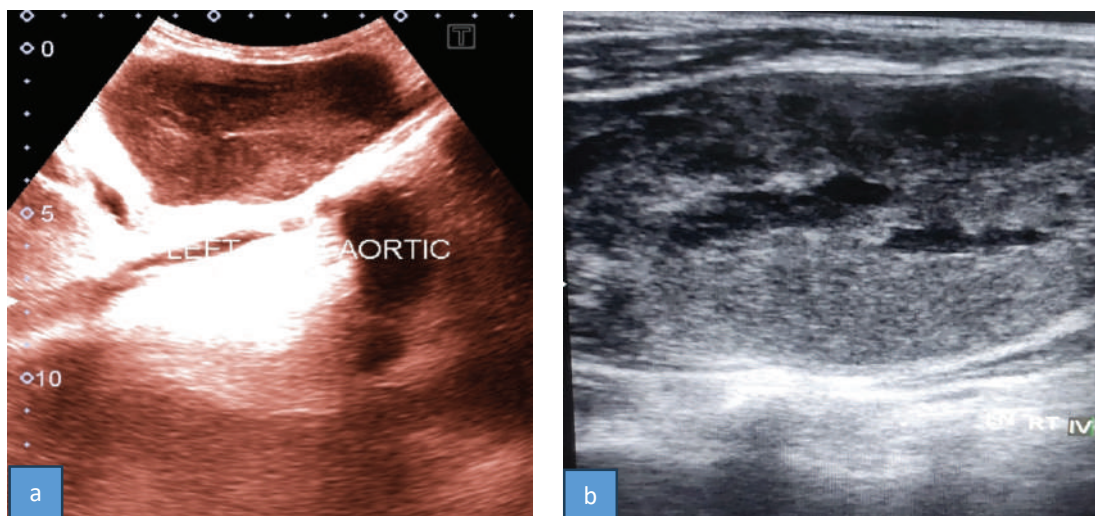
Ultrasound examination of a patient of PTC with persistently low Tg level showing multiple enlarged abdominal lymph nodes at left paraaortic (a) and right sided cervical (b) regions with loss of nodal architecture suggesting nodal metastases.
